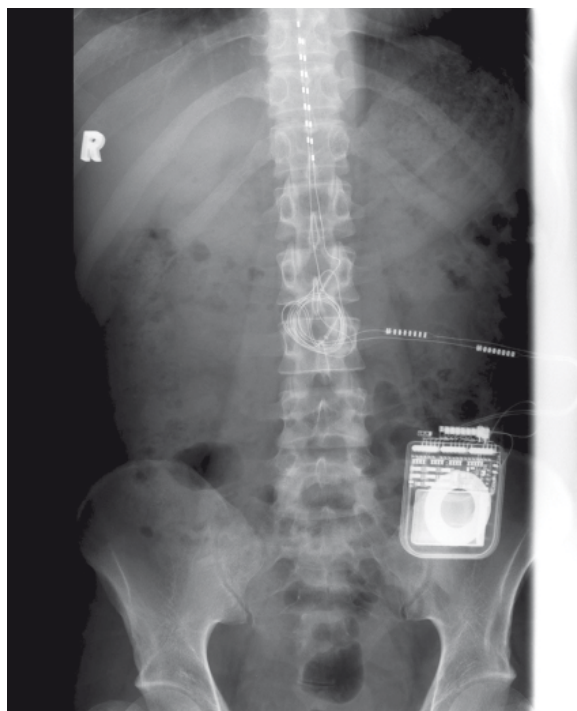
Radiograph showing the spinal cord stimulator system consisting of a subcutaneous implantable pulse generator with dual octrode leads placed at T10-12 level.
